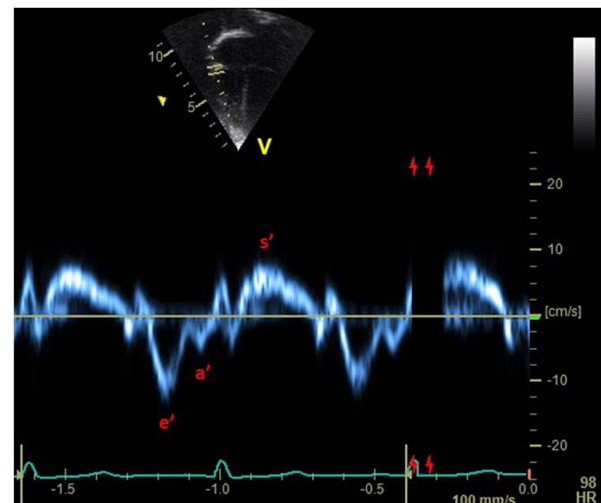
Pulse wave spectral Doppler of the right ventricular free wall at the level of the tricuspid valve annulus to obtain tissue Doppler imaging early-diastolic wave (e'), late-diastolic wave (a'), and systolic wave (s').
